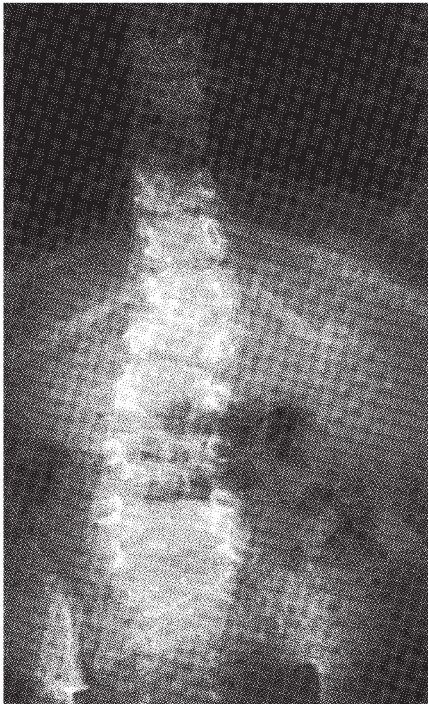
Follow-up radiograph (at 29 months) showing maintenance of initial curve correction.
